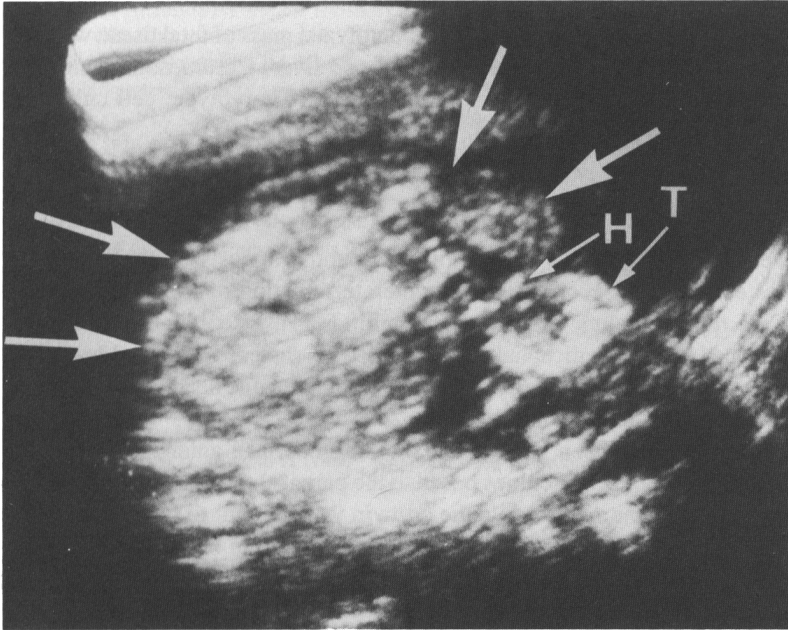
Ultrasonogram showing a transverse section through the lowermost part of the fetal thorax. The boundaries of the extracorporeal tissue are demarcated by four arrows. H, fetal heart; T, fetal thorax.
